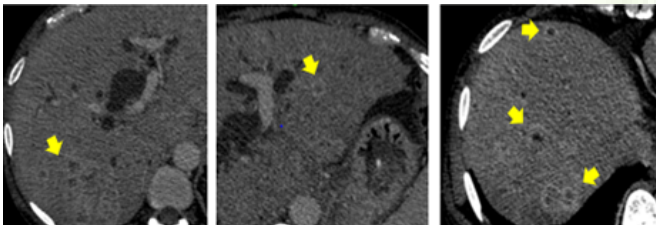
Cholangitic abscess. Axial sections of CT portal venous phase images showing multiple small peripherally enhancing hypodense lesions (yellow arrows) in both lobes of liver in case of a distal cholangiocarcinoma.
